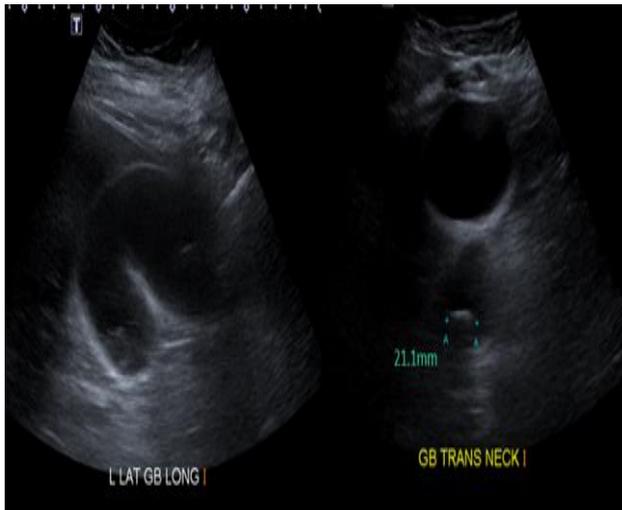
Ultrasound demonstrating thin-walled gallbladder and a 21 mm stone in gallbladder neck.
